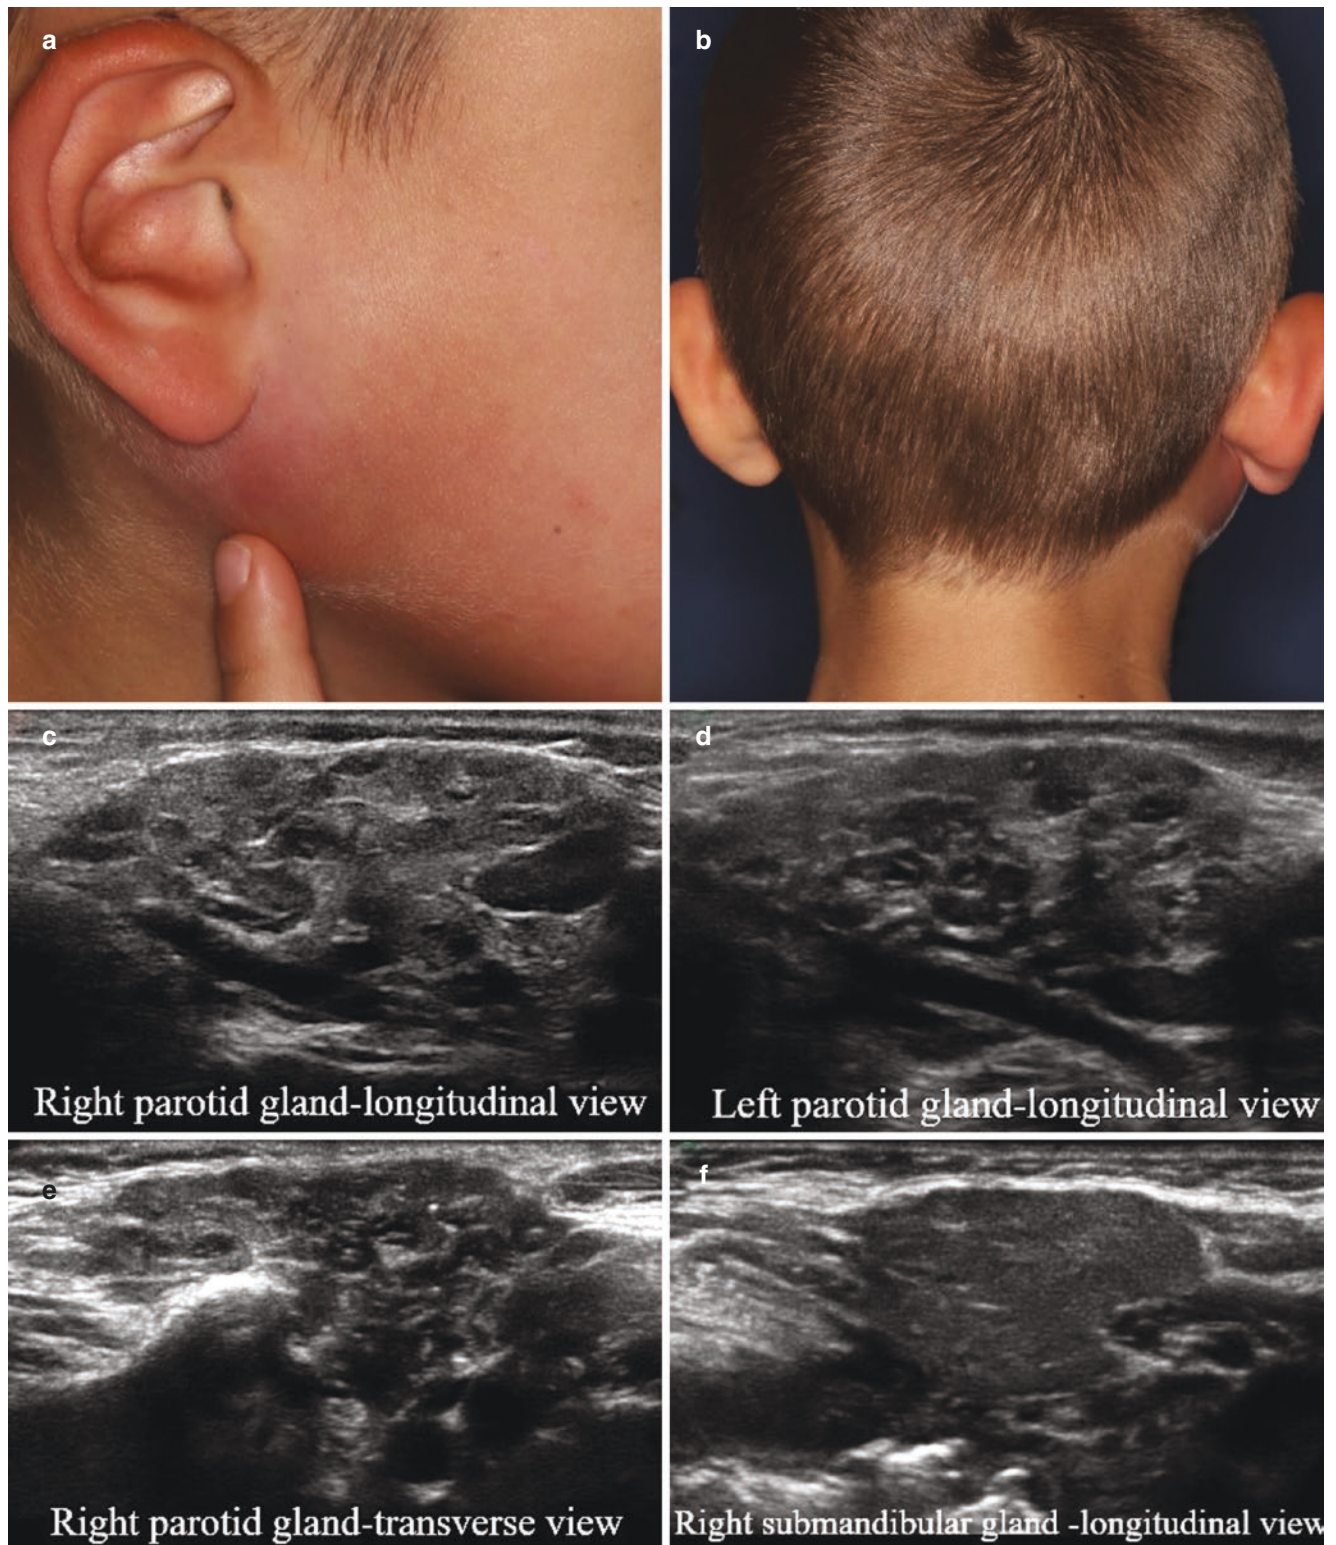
Since 7 years of age, a 7-year-old boy has suffered from recurrent right parotitis (a, b) and xerostomia. His clinical presentation with negative anti-SSA/SSB mimics juvenile recurrent parotitis. The ultrasound images show a characteristic heterogeneity of the parenchyma
